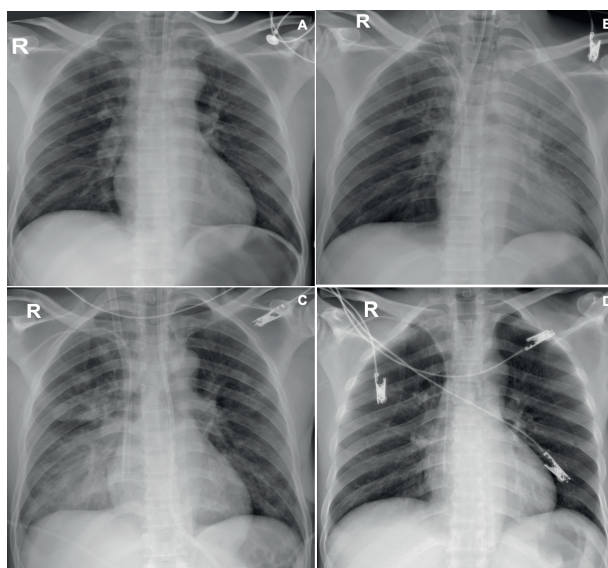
Sequential chest x-ray of case 6. A. Normal cardio aortic silhouette, central trachea, normal mediastinum, orotracheal tube in proper position. There are no consolidations, adequate pulmonary expansion. An image is observed that may correspond to a probe projected to the right intermediate bronchus. B. central trachea, orotracheal tube correctly positioned, right jugular cannula ending in the right atrium. Appearance of consolidation with air bronchogram in the left upper lobe. C. Opacity in the right lower lobe, ECMO cannula in position, enteral feeding tube. There is no evidence of pleural effusion. This image is posterior to the extraction of the foreign body located in the right intermediate bronchus. D. Image prior to discharge showing a normal trachea, normal cardiac silhouette, mediastinum and lung fields. There is no evidence of pneumothorax or pleural effusion.
